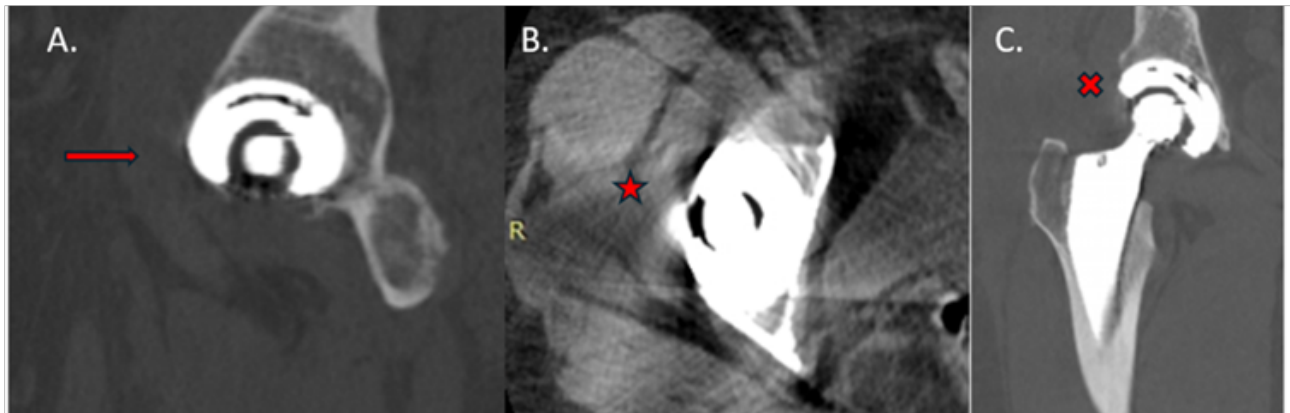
(A) Sagittal CT scan of the right hip showing contact between the insert and the psoas tendon (red arrow). (B) Axial CT scan with a star marking a hypodense, ill-defined region related to the iliopsoas tendon and the liner. (C) Coronal CT scan with an X indicating a lower-density area near the lateral edge of the femoral stem neck.
